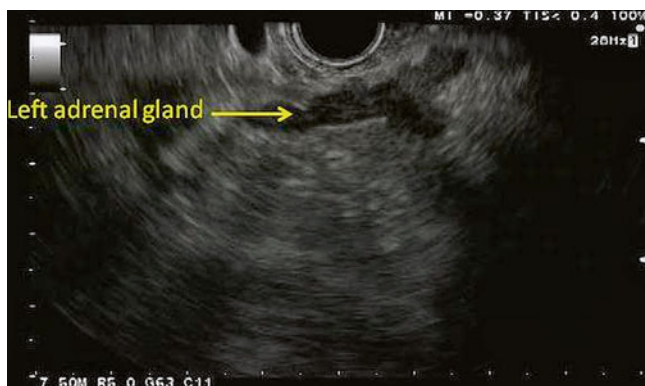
Depicted here is the typical sonographic appearance of a left adrenal gland. It is a V- or Y-shaped organ with a hypoechoic cortex and a hyperechoic inner medulla
